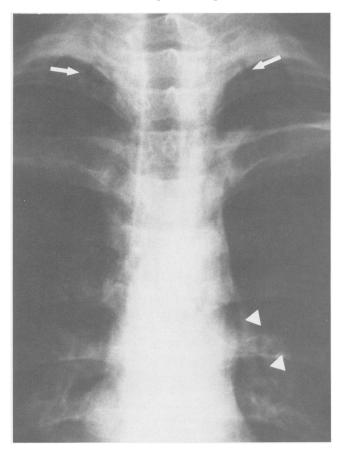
An anterolateral chest radiograph shows pneumomediastinum (arrowheads) and dissection of air into the subcutaneous tissues of the neck (arrows).
